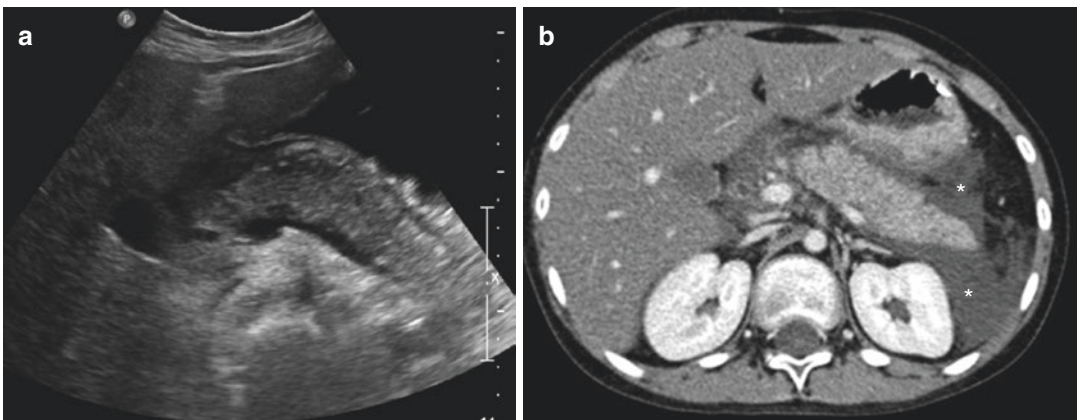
During treatment with L-asparaginase for ALL, this 12-year-old boy developed acute pancreatitis. On US (a) and CE-CT (b) the pancreas is diffusely enlarged and there is intra- and retroperitoneal free fluid (*)
